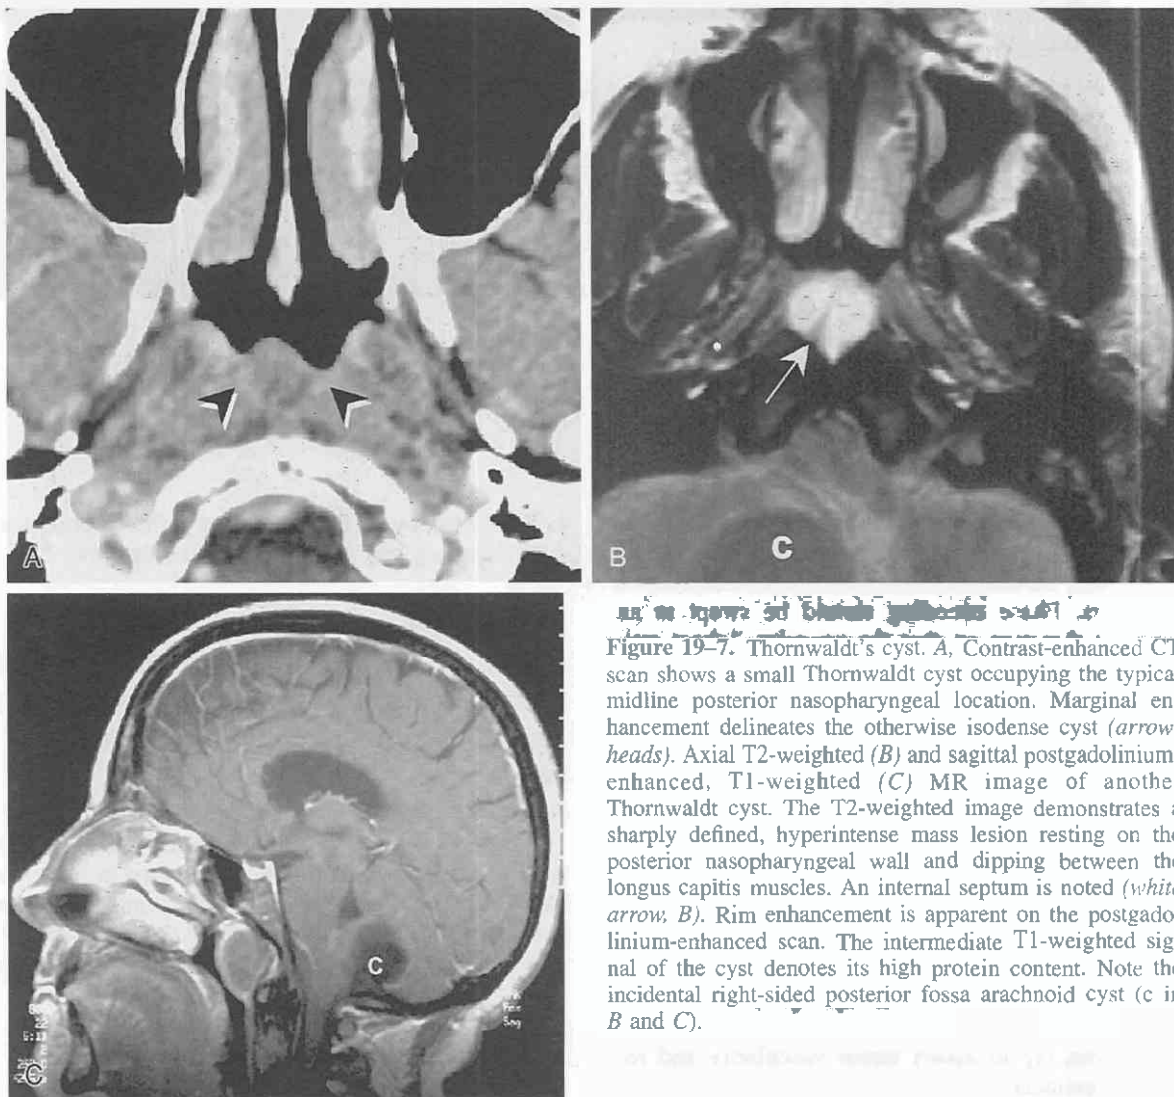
Thornwaldt's cyst. A, Contrast-enhanced CT scan shows a small Thornwaldt cyst occupying the typical midline posterior nasopharyngeal location. Marginal enhancement delineates the otherwise isodense cyst (arrowheads). Axial T2-weighted (B) and sagittal postgadolinium-enhanced, T1-weighted (C) MR image of another Thornwaldt cyst. The T2-weighted image demonstrates a sharply defined, hyperintense mass lesion resting on the posterior nasopharyngeal wall and dipping between the longus capitis muscles. An internal septum is noted (white arrow, B). Rim enhancement is apparent on the postgadolinium-enhanced scan. The intermediate T1-weighted signal of the cyst denotes its high protein content. Note the incidental right-sided posterior fossa arachnoid cyst (c in B and C).
